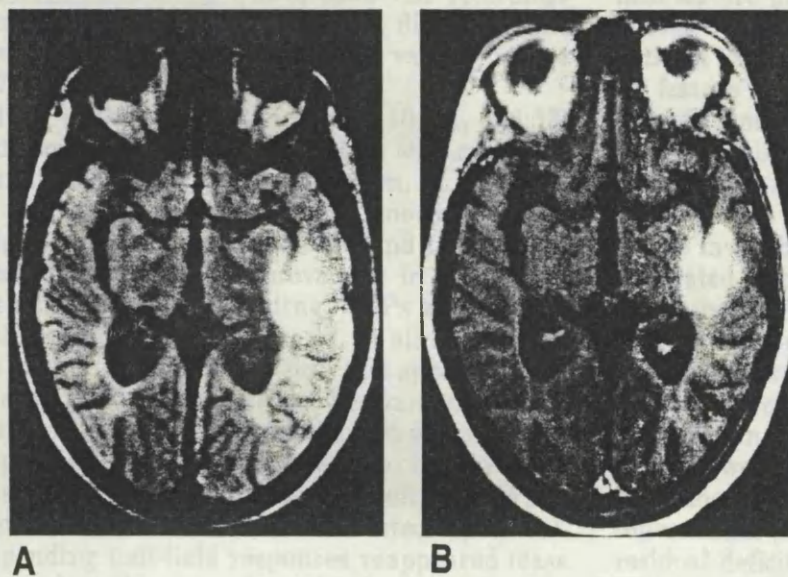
(Case 17) (A) T_2 -weighted MRI ($SE_{2000/40}$) following acute onset of a right homonymous hemianopia. A large high-signal area is seen in the left temporal lobe, extending deeply. (B) On a T_1 -weighted sequence ($SE_{500/40}$) the lesion displays gadolinium enhancement.
